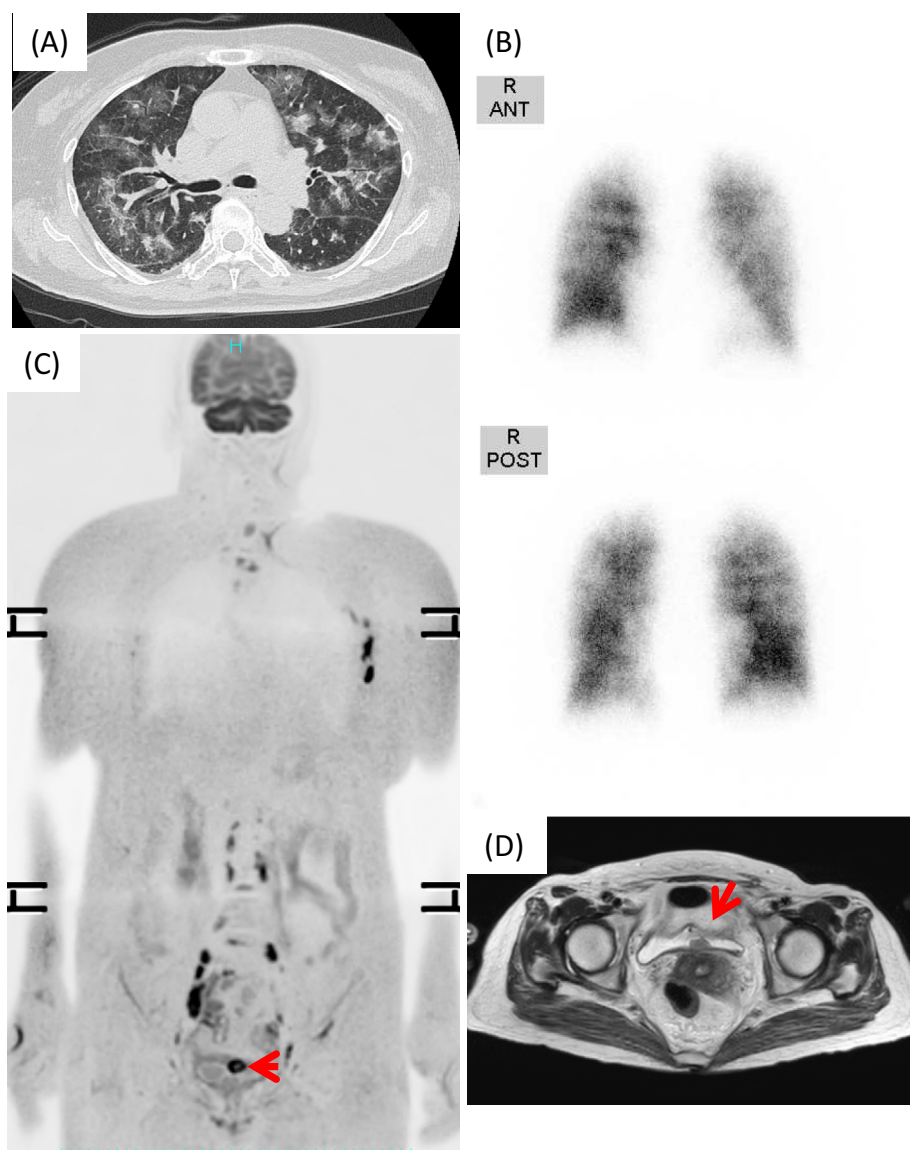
(A) Contrast-enhanced chest CT revealing diffuse patchy infiltrates in the bilateral lung fields. (B) Lung perfusion scintigraphy using ^{99m}Tc -MAA showing multiple peripheral perfusion defects in the bilateral lungs. (C) Whole-body DWI showing high-signal-intensity regions in the urinary bladder (arrow), left axillary lymph nodes, and intraabdominal lymph nodes. (D) T2-weighted imaging showing a mass lesion on the urinary bladder wall, consistent with the high-signal-intensity region on whole-body DWI (arrow).
